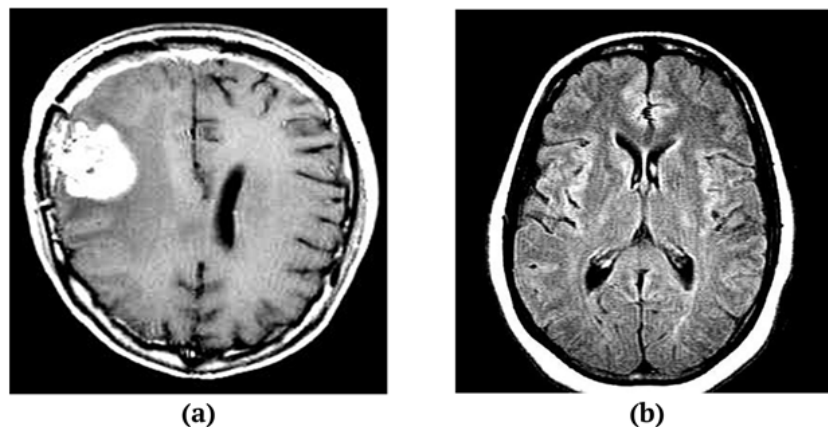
Brain MRI images (a) with brain tumor (b) without brain tumor.
